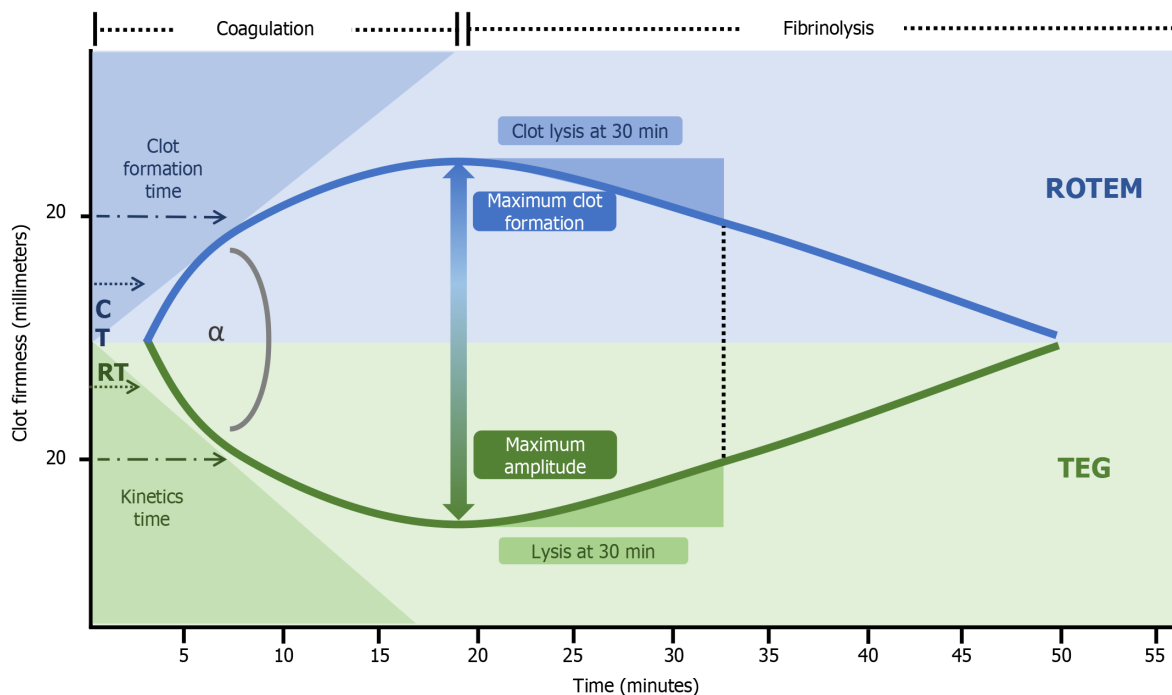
Clot formation and lysis sections in rotational thromboelastometry and thromboelastography tracings. Detailed explanation is in Table 1. CT: Clotting time; RT: Reaction time; ROTEM: Rotational thromboelastometry; TEG: Thromboelastography.
